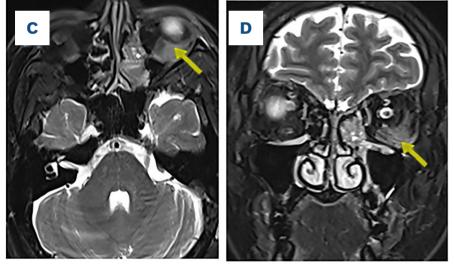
Orbital magnetic resonance imaging demonstrating orbit involvement. (A) Axial FLAIR sequence reveals a hyperintense signal in the left posterior sclera at the optic nerve insertion into the globe (yellow arrow). (B) Axial T1-weighted sequence with fat suppression after gadolinium injection demonstrates contrast enhancement of the left posterior sclera (yellow arrow). (C, D) Axial and coronal T2-weighted sequences, respectively, show a hyperintense, poorly demarcated orbital lesion located posterior and inferior to the left globe (yellow arrows), most consistent with an orbital chloroma.
